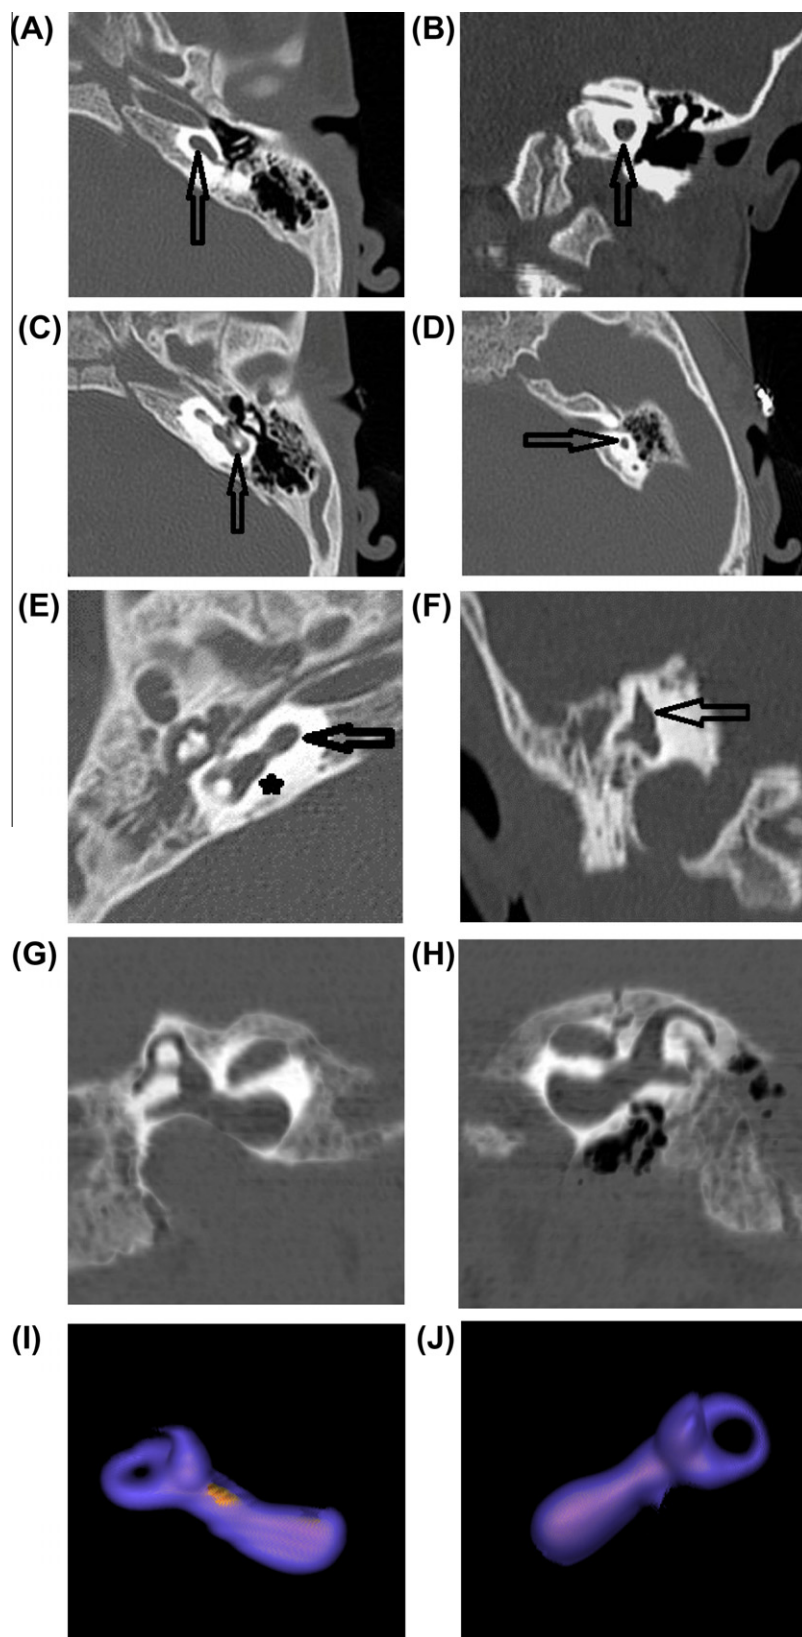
Showing a case of bilateral D1,2,3,4 anomalies. Dysmorphic components of the labyrinth are shown, the cochlea (D1 anomaly, arrows in A,E), vestibule (D2 anomaly, arrow in B and star in E), lateral SCC (D3 anomaly arrow in C), superior SCC (D4 anomaly arrows in D,F). (A, C, D) Axial CT image for the left side. (B) Axial for left side. E and F axial and coronal for the right side. (G, H) Min. IP and I, J VR images of the entire labyrinth for the right and left sides, respectively.
